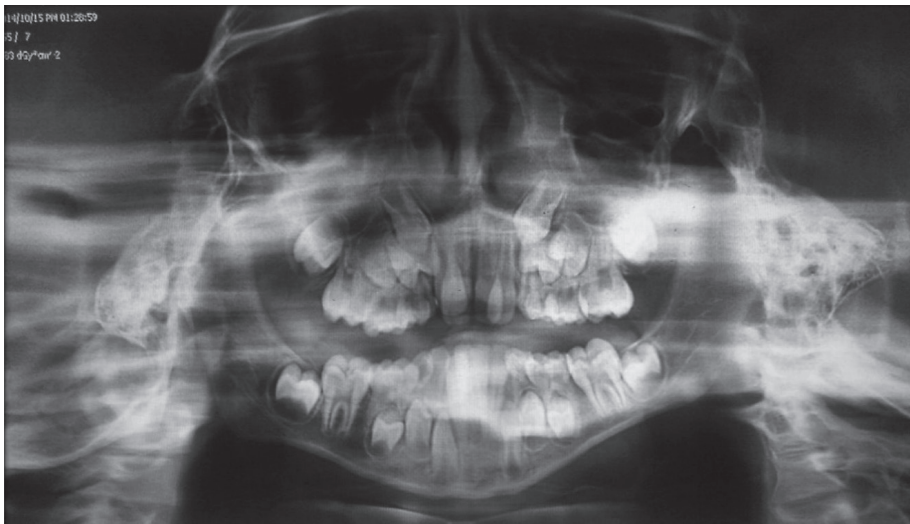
Panoramic radiograph showing crowding of teeth and multiple carious teeth.
